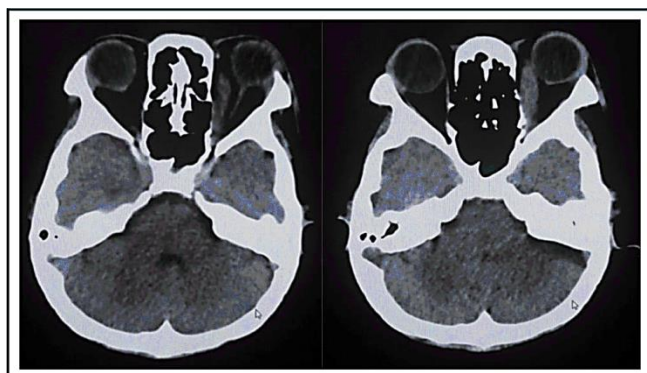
CT scan with left proptosis.
